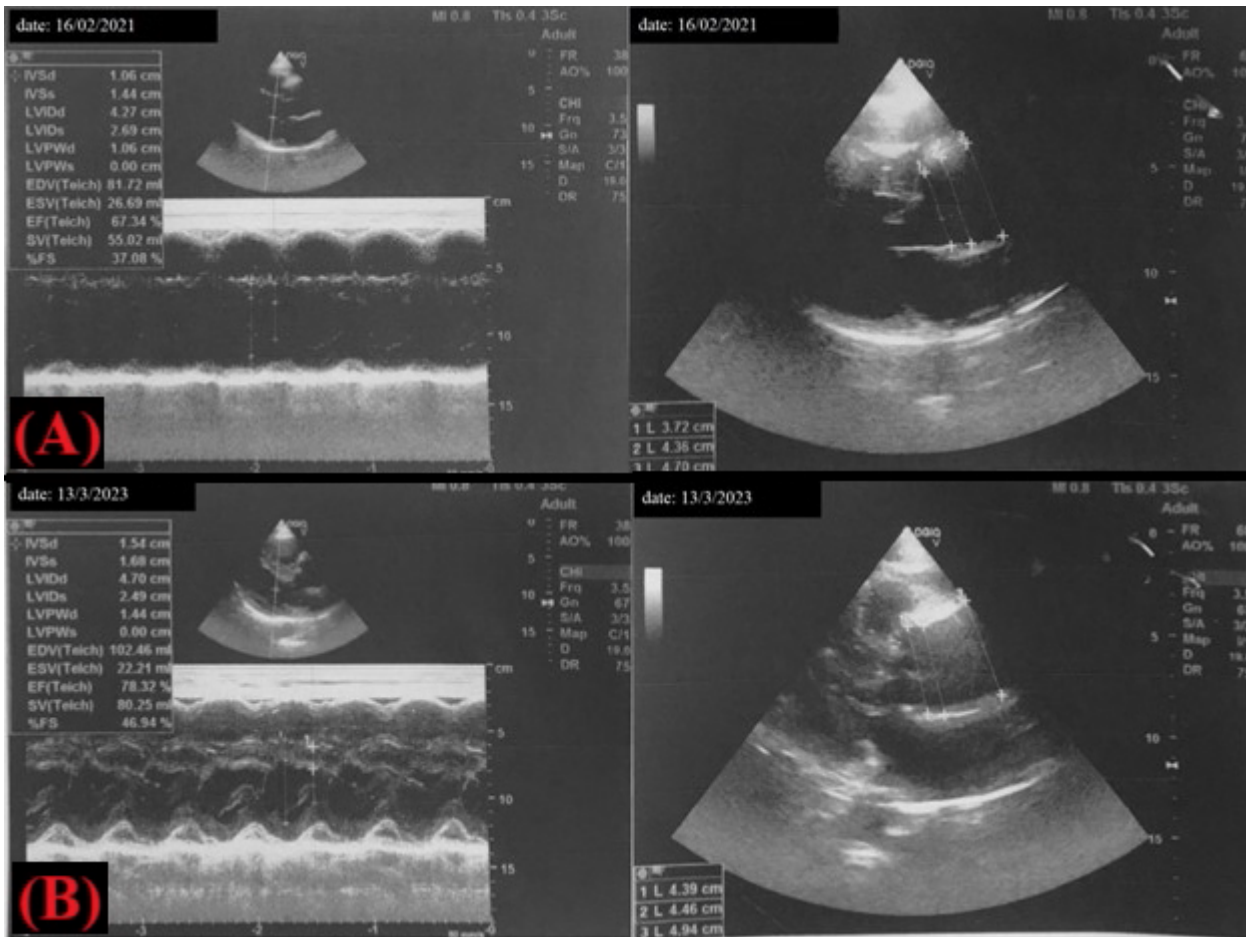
Echocardiogram studies. A) Baseline echocardiogram showing dilated aortic root from the sinus and proximal ascending aorta measuring 37 mm, 43 mm, and 47 mm, respectively; B) follow-up echocardiogram showing aortic root and sinus measuring 43, 44, and 49-50 mm, respectively.
